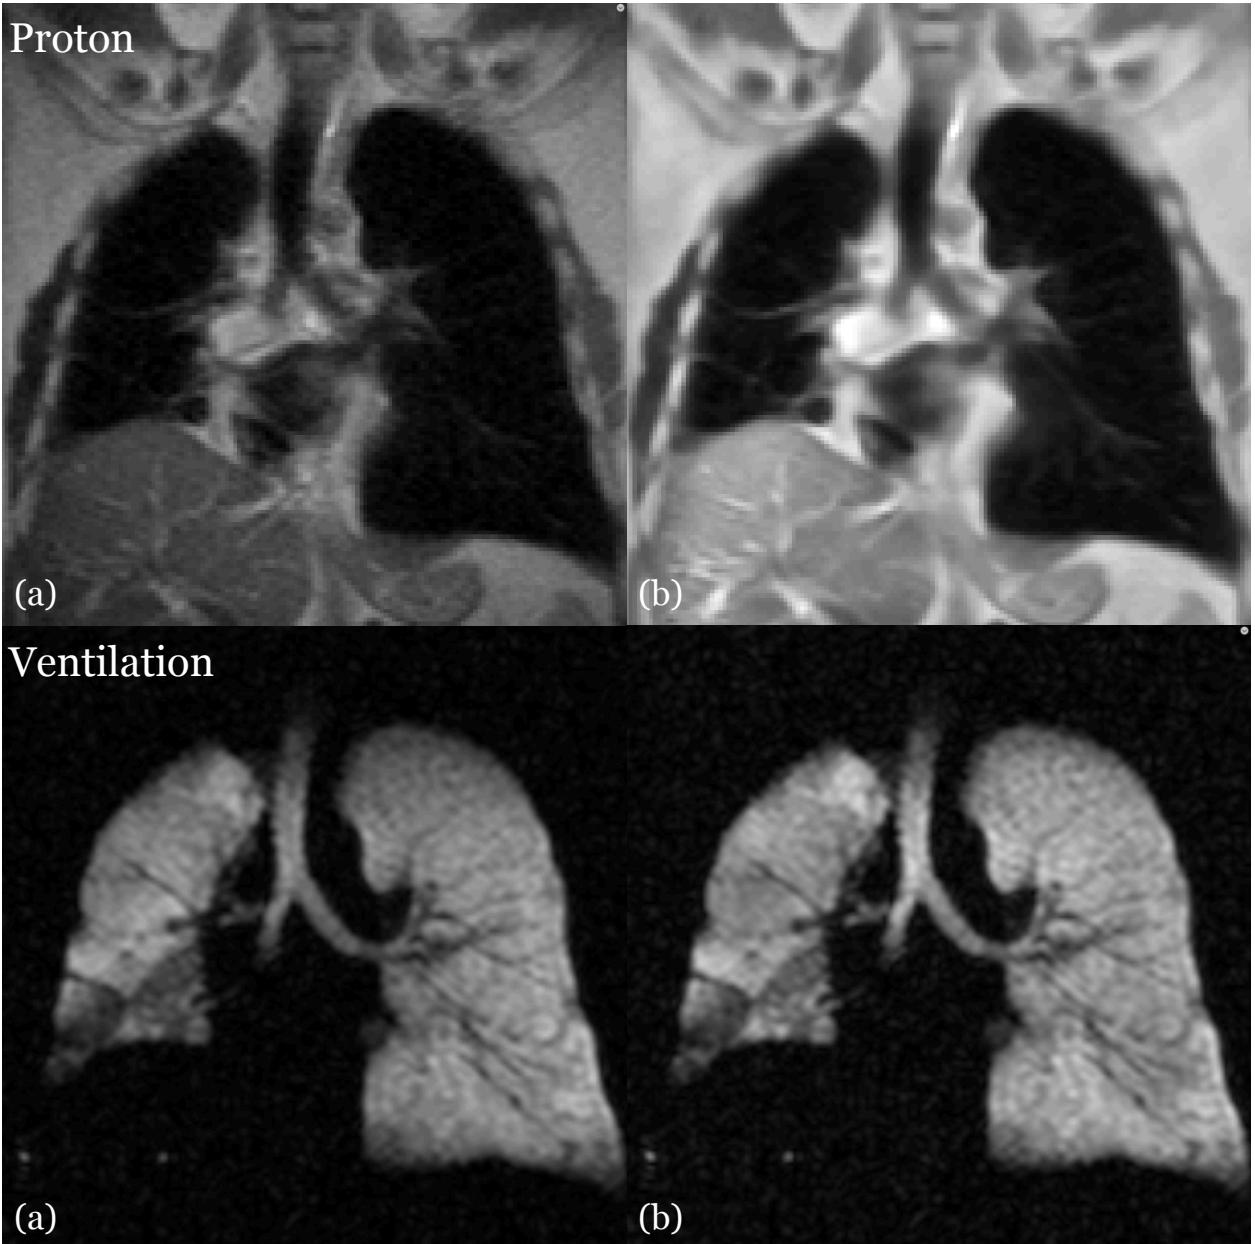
Side-by-side image comparison showing the effects of preprocessing on the proton (top) and ventilation (bottom) MRI. (a) Uncorrected image showing MR field inhomogeneity and noise. (b) Corresponding corrected image in which the bias effects have been ameliorated.
